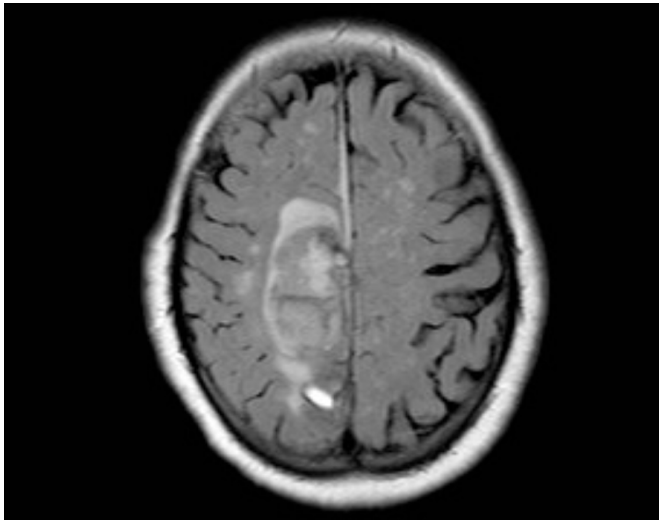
Preoperative CT brain showing right intracranial bleed.
